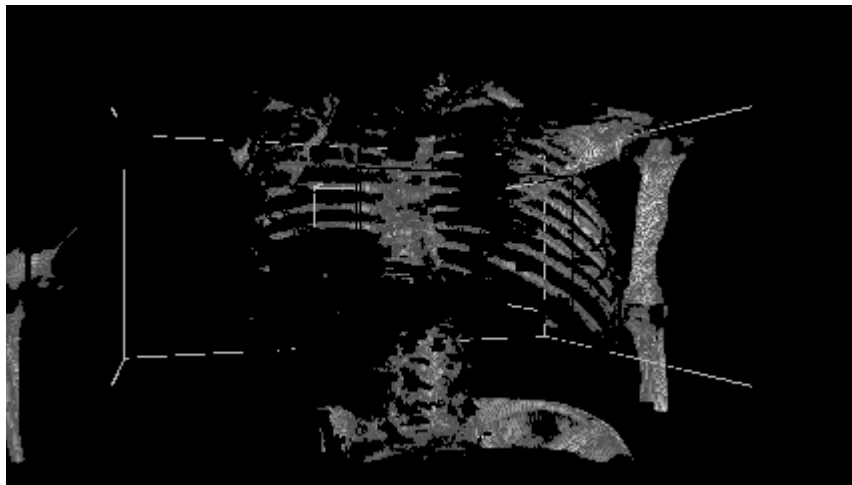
Positive parallax of left CT projection.
